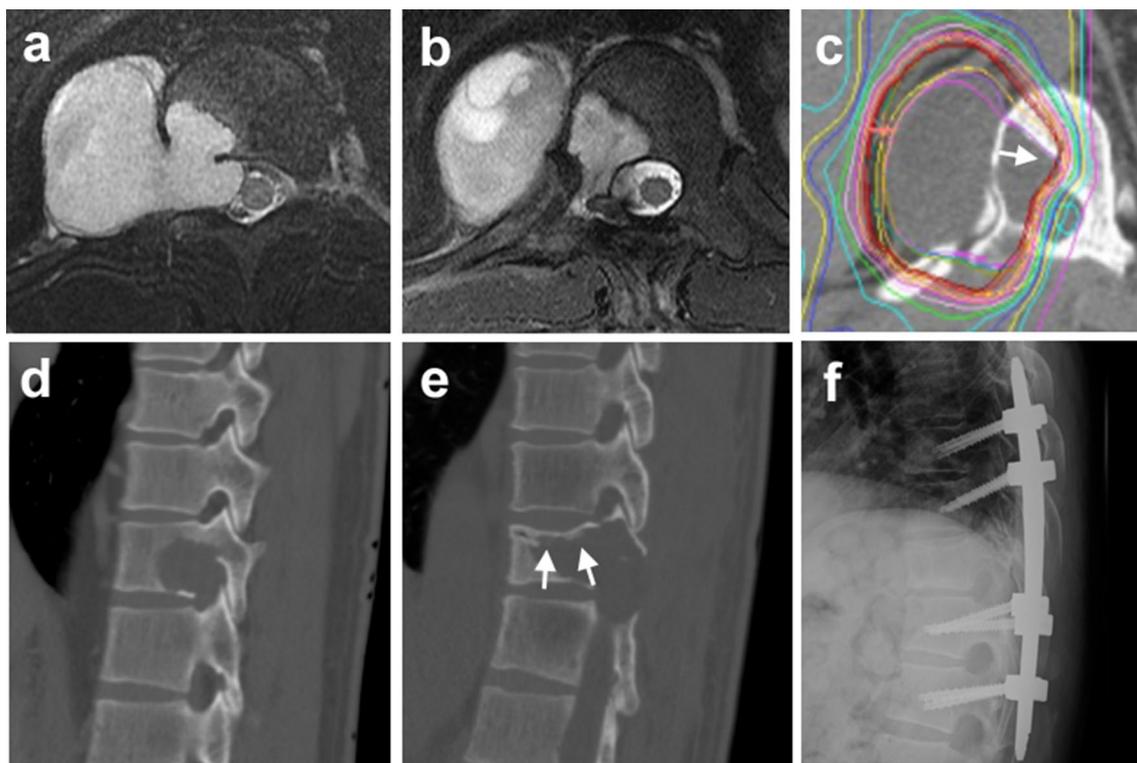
Case 8. A 49-year-old man with MPNST at T11 and T12. a, b Axial T2-weighted MRI reveals a paravertebral neoplastic lesion with an intraspinal lesion. Preoperative (a) and postoperative (b) ESCC was regarded as Grade 2 and Grade 1b, respectively. c Planning of CIRT. The 90% isodose line (red line indicated by arrow) was set
